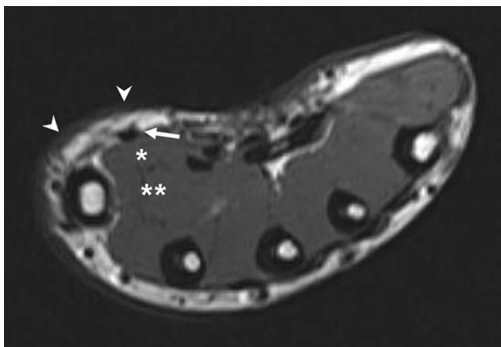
MRI axial image shows flexor pollicis brevis and abductor pollicis brevis agenesis.
